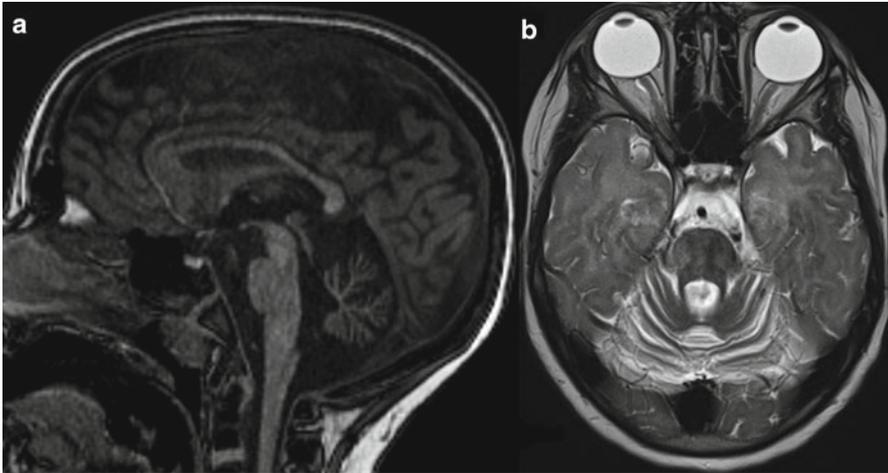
8.5-year-old girl with progressive ataxia caused by 4H syndrome and *POLR3A* mutation. (a) Midsagittal T1- and (b) axial T2-weighted images show enlarged fissures (interfolial spaces) within the cerebellar vermis and hemispheres representing cerebellar atrophy. In addition, the white matter shows a T2-hyperintense signal representing hypomyelination
